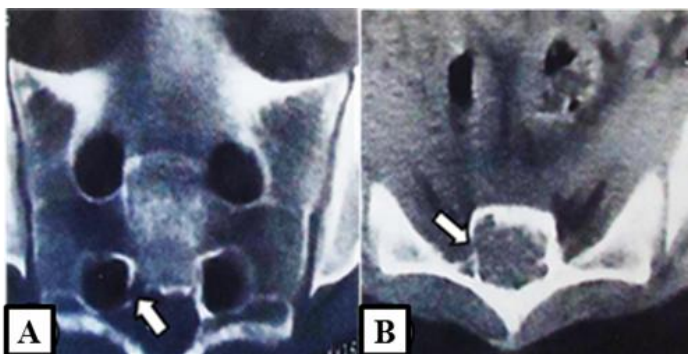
CT image of giant cell tumor of the sacrum (coronal and transverse projections)
